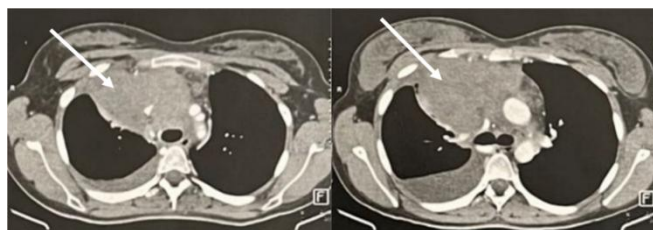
Computed tomography of an anterior mediastinal inflammatory myofibroblastic tumor, the arrow points to the tumor
